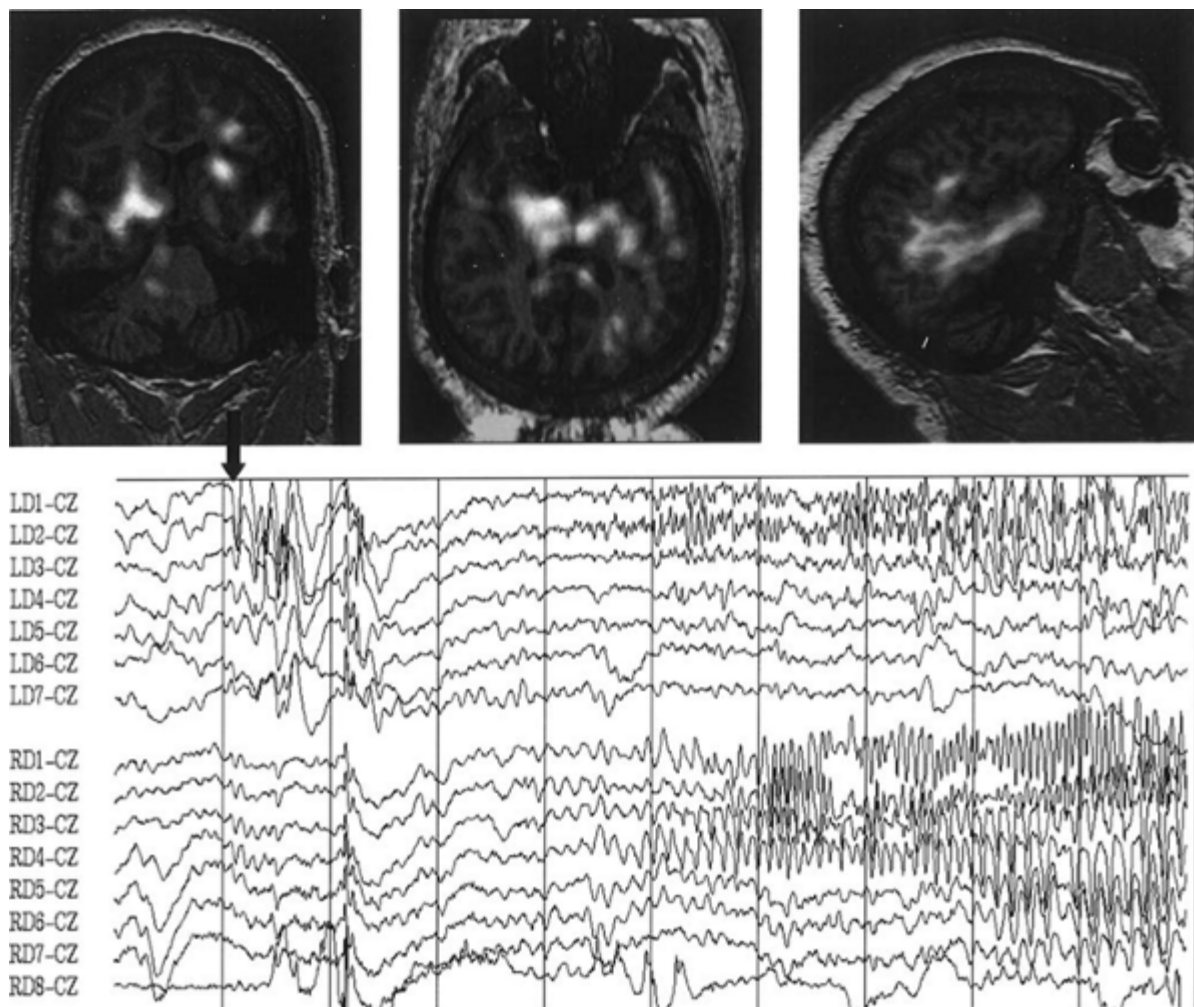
Subtraction ictal SPECT (single photon emission computed tomography) coregistered on MRI
